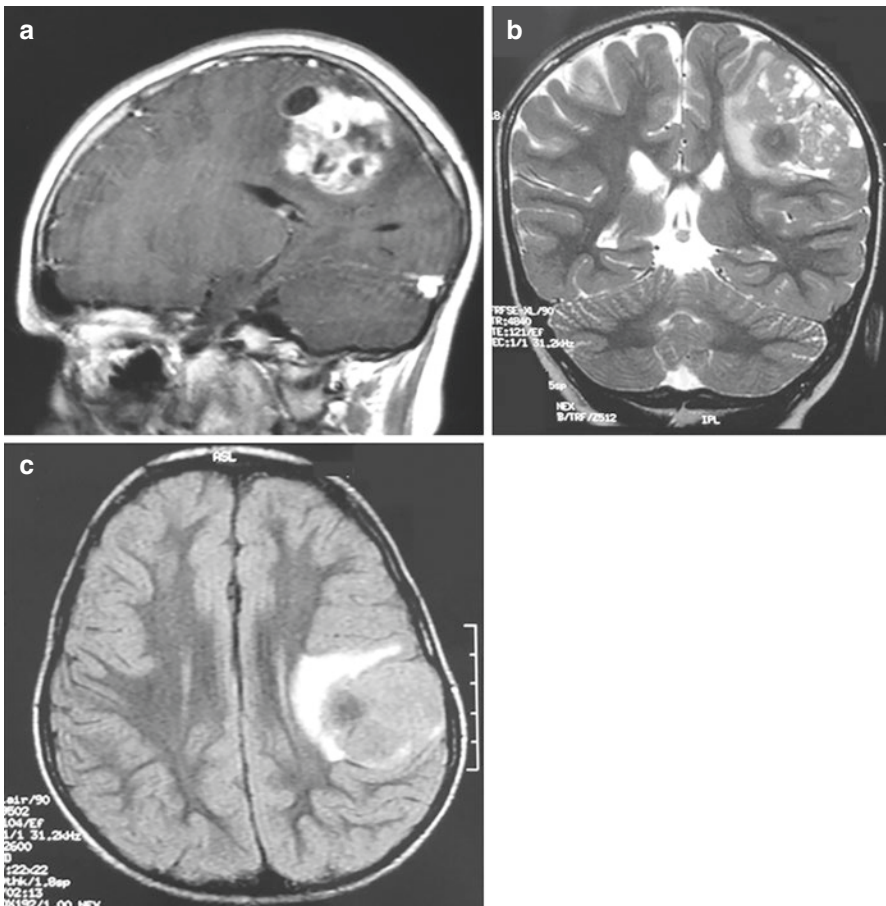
A case of a 10-year-old boy presented with a 2 week history of headache and vomiting. (a) Sagittal gadolinium-enhanced T1-weighted MRI of a supratentorial ependymoma exhibiting areas with solid and cystic components. T2-weighted (b) and FLAIR MRI (c) showing peritumoral oedema
